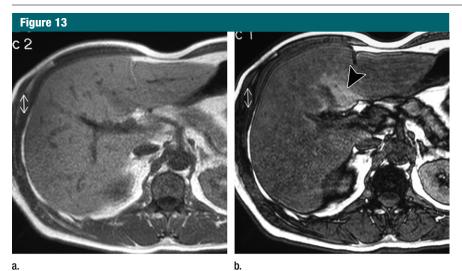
MR images in a 45-year-old man with focal fatty sparing in segment 4. (a) In- and (b) opposed-phase GRE T1-weighted images (236/2.2 and 4.4; flip angle, 80°; section thickness, 4 mm) show drop of signal intensity in the liver on opposed-phase image related to steatosis. Focal fatty sparing is seen in the posterior part of the segment 4 (arrowhead). (c) On contrast-enhanced GRE T1-weighted image (4.5/2.2; flip angle, 10°; section thickness, 4 mm) obtained at the portal phase, a right gastric vein enters directly in segment 4 (arrow).
